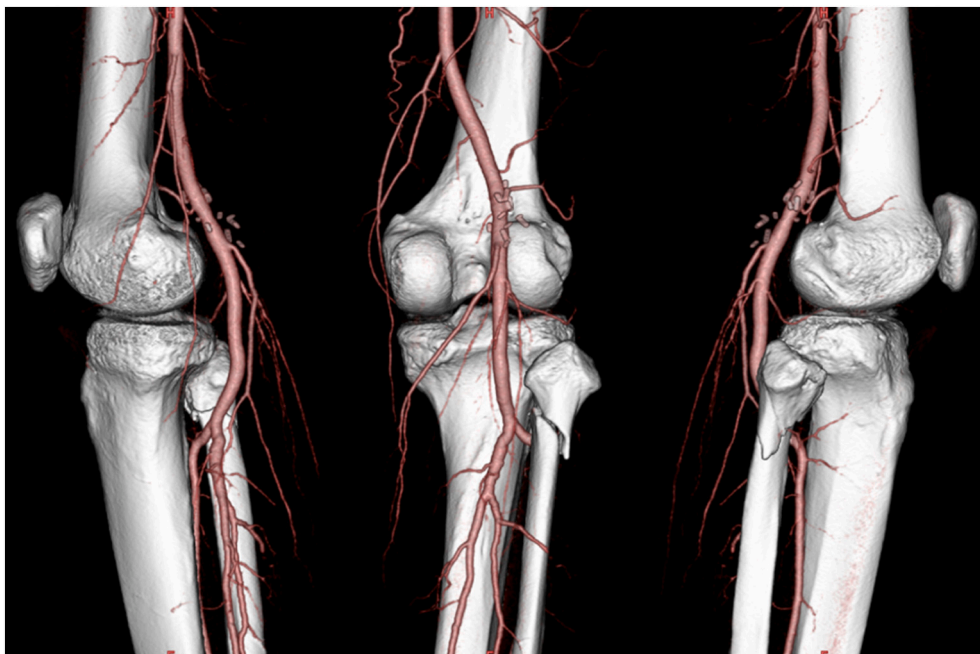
Immediate postoperative computed tomography angiography (CTA). It shows that the popliteal artery is patent and without stenosis.
